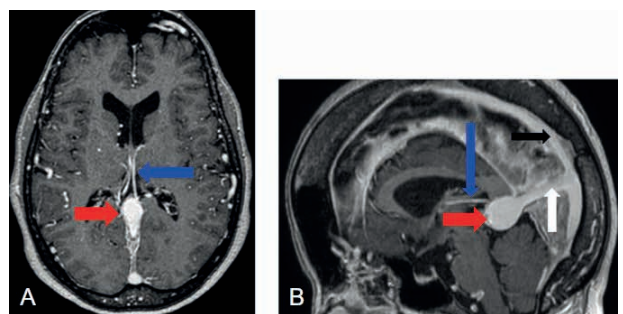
Cranial MRI in post-contrast T1-weighted images, axial section (A) and sagittal section (B), demonstrating choroidal arteries branching from the posterior cerebral arteries (blue arrow), aneurysmal dilation of the Vein of Galen (red arrow), falx cerebri (white arrow), and superior sagittal sinus (black arrow).
